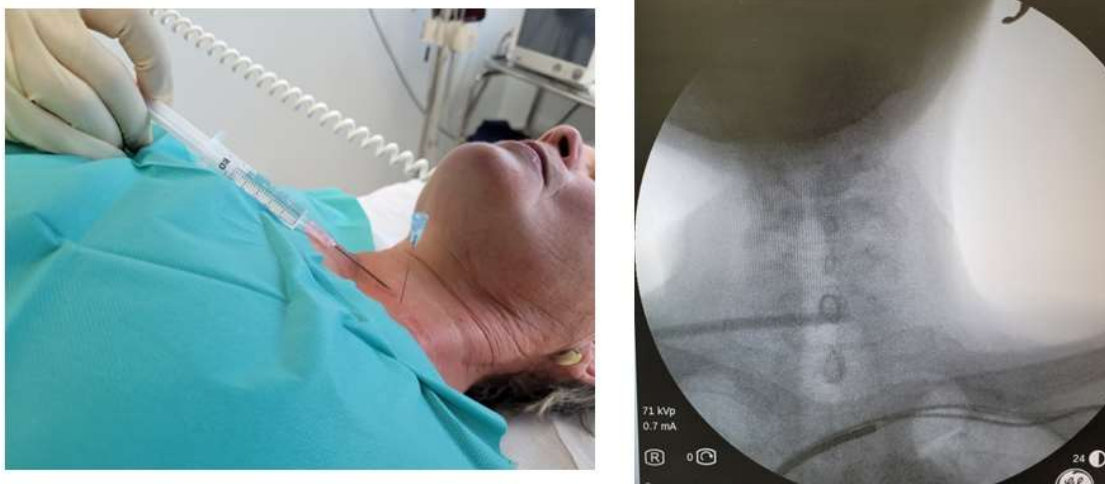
Localization of the needle placement during a stellate ganglion blockade under X-ray control, infiltration of the area with local anesthesia (Author's archives).
